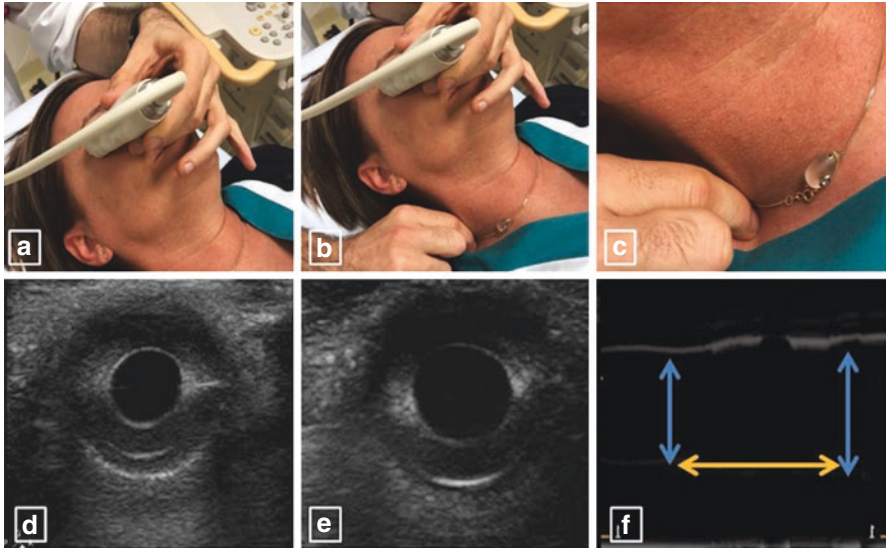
Ultrasound assessment of ciliospinal reflex (CR). (a) Initial probe posing; (b) elicitation of CR; (c) site of stimulation; (d) B-mode visualization of pupil at rest; (e) B-mode visualization of pupil in mydriasis after stimulus; (f) M-mode measurement of pupillary diameter (in blue) and pupillary dilation time (in yellow)
